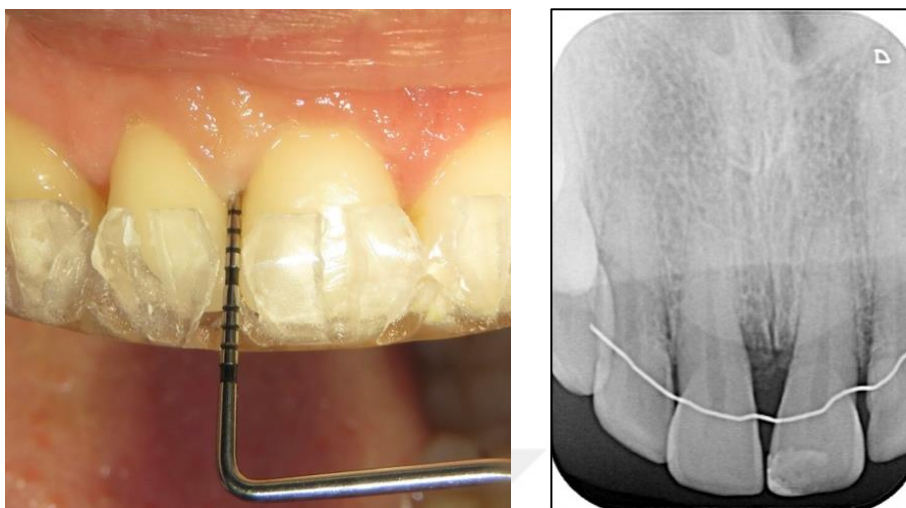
b. Baseline PPD measurement and diagnostic periapical radiographic view
